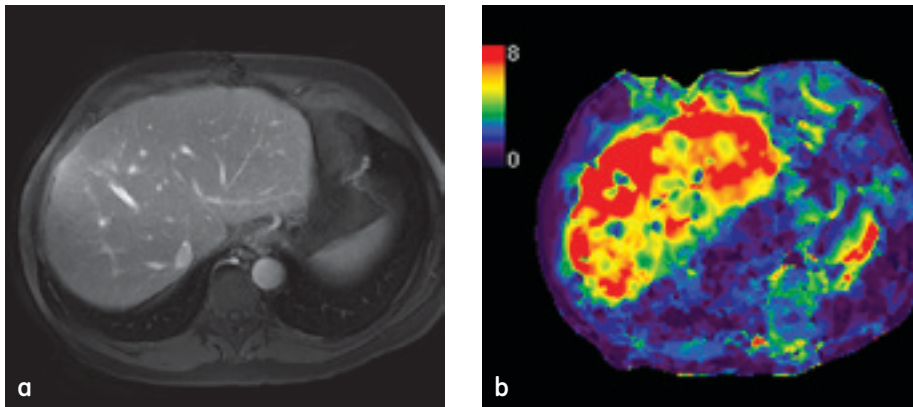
(a) MR image from December 2009, (b) MRE at this time shows stiffness levels consistent with moderate to marked fibrosis.
